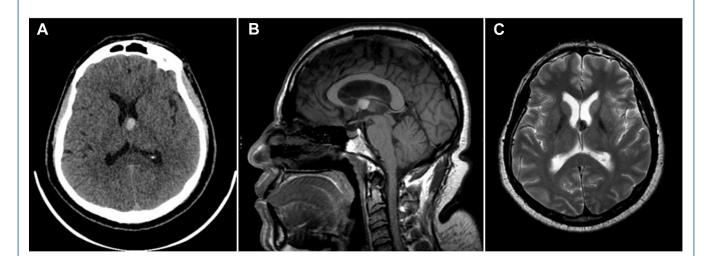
(A) Nonenhanced computed tomography scan showing a well-defined hyperdense lesion representing a colloid cyst in the anterior third ventricle, extending to the left foramen of Monro, causing mild
